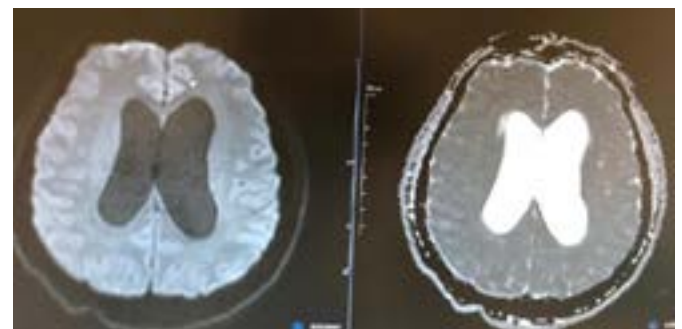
The patient's brain MRI axial image
